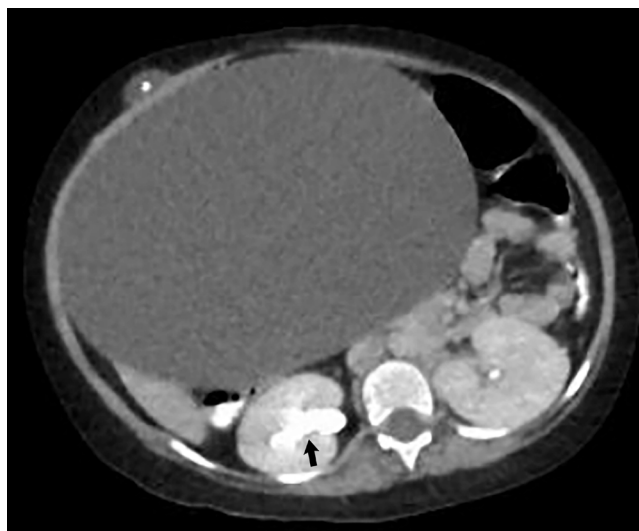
Contrasted abdominal CT (axial) demonstrated widening of right kidney pelvicalyceal system
